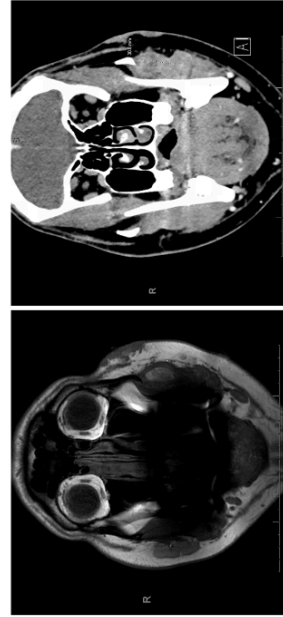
including CT neck/MRI face which demonstrated a heterogeneously enhancing nodule with the left masseter muscle measuring 2.3 x 1.7 x 3.1 cm (AP X TR X CC) and multiple subcutaneous nodules in the areas of overlying skin change which included nodules along the left cheek, temporalis fossa, and periorbita (Figure 2).
